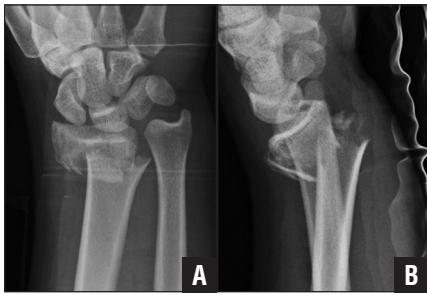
Posteroanterior (A) and lateral (B) radiographs of a typical extra-articular distal radius fracture suitable for fixation with the threaded pin device.
